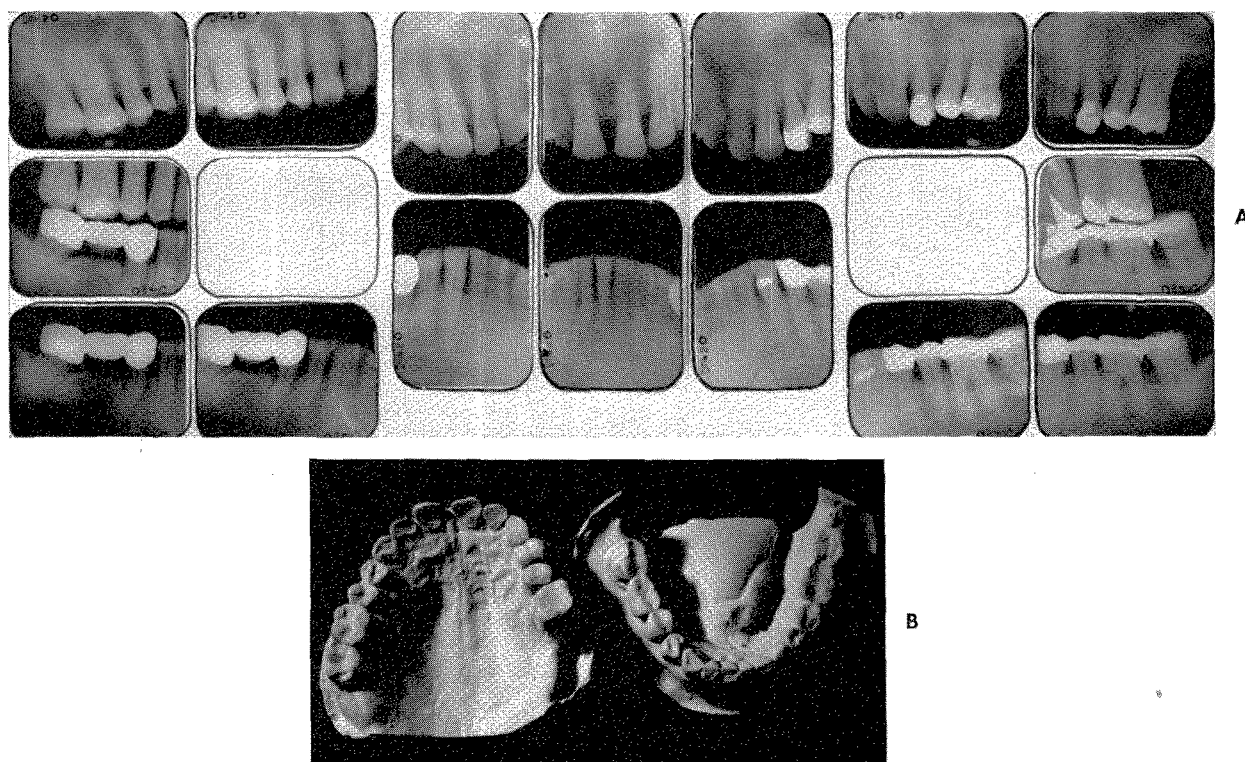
A, Roentgenograms of the patient whose teeth are shown in Fig. 662. The periodontal and osseous tissues are in a state of deterioration. B, Casts of the teeth of the patient. The abrasion and attrition are evident.
